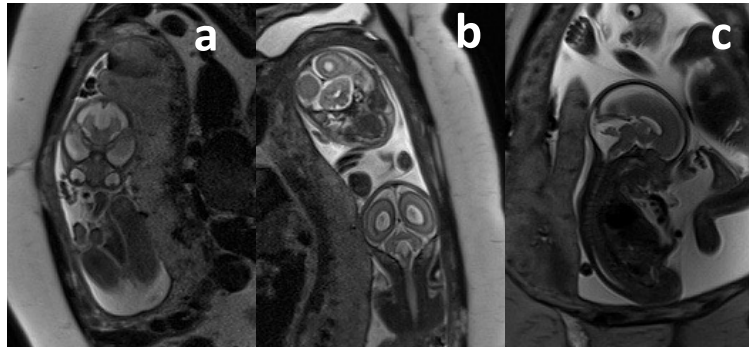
MRI Imaging at 21+4 GW (twin pregnancy): DWM is visible in one of the two fetuses (a,b,c)
